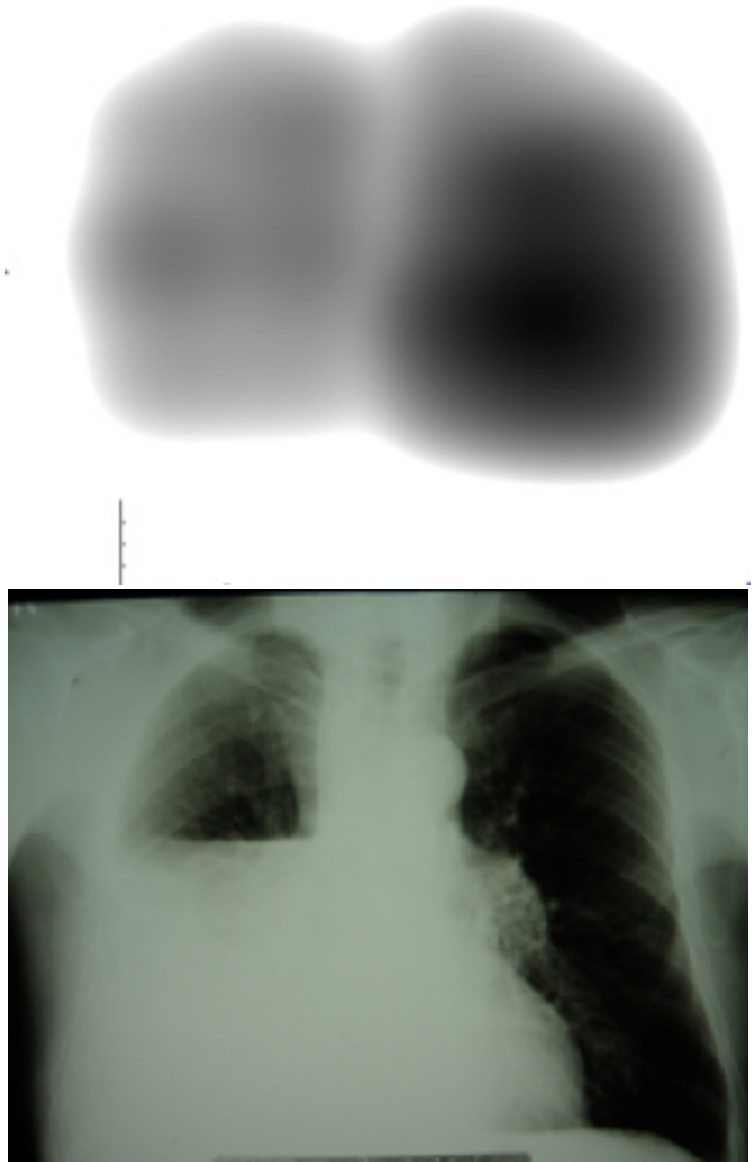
Comparison of findings in VRI and lung x-ray - liquidothorax
